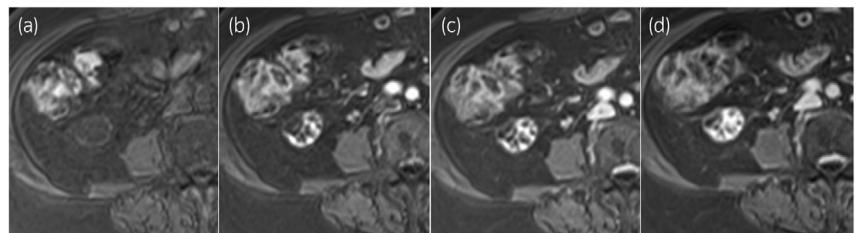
Dynamic contrast-enhanced MRI (a: pre-, b: 30 s, c: 70 s, and d: 300 s after gadolinium injection) revealed rapid cribriform enhancement at the posteromedial peripheral area of the tumor in the arterial phase (b). A progressive filling-in pattern is shown in the delayed phases (c, d).
